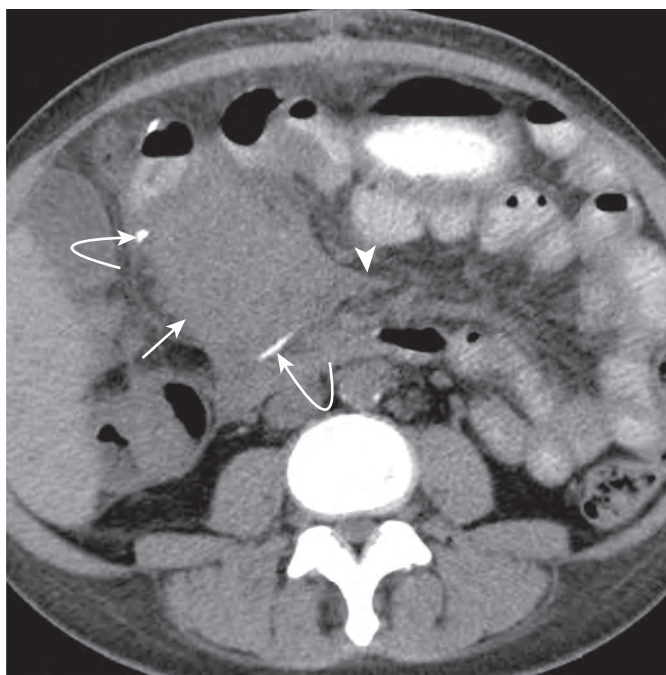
CT appearance of nonspecific pancreas transplant edema, later shown to be acute rejection on biopsy. Unenhanced axial CT image demonstrates the pancreas transplant (arrow) as an ill-defined soft tissue structure in the right lower quadrant, difficult to distinguish from unopacified small bowel in the absence of intravenous contrast material but identified by duodenal stump suture lines (curved arrows). There is a small amount of adjacent free fluid (arrowhead). (From Vandermeer F, Manning MA, Frazier A, et al: *Imaging of whole-organ pancreas transplants*. *RadioGraphics* 32:411–435, 2012.)
